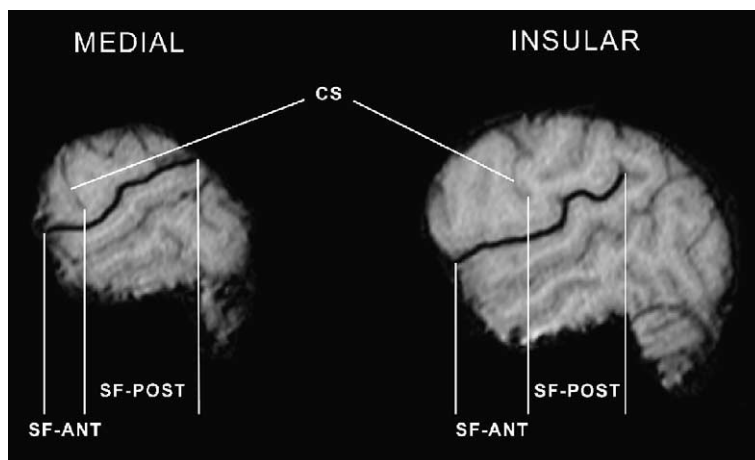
MRI images from the sagittal plane of a chimpanzee brain demonstrate the scans that were identified as the Medial and Insular regions for measurements of SF-ANT and SF-POST (traced in black). CS: central sulcus.
